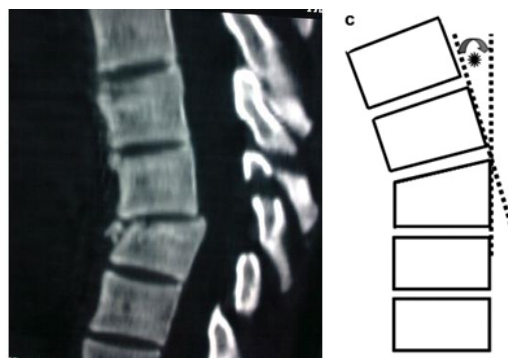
CT L-S spine sagittal reformation, L1 compression fracture and calculation of kyphotic angle.
